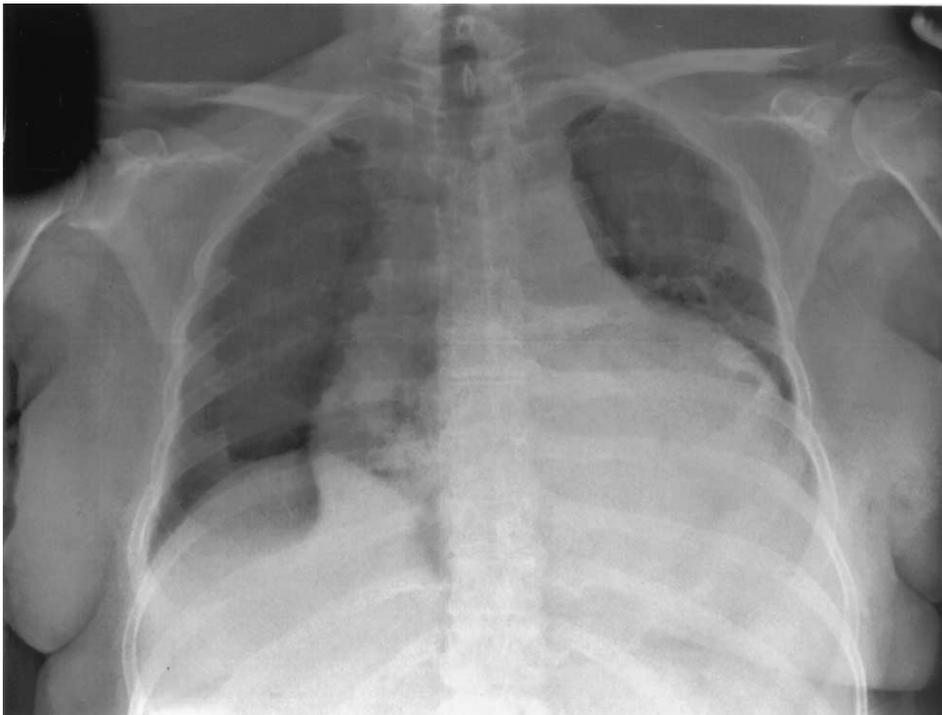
Chest radiograph showing bilateral convex heart enlargement.
